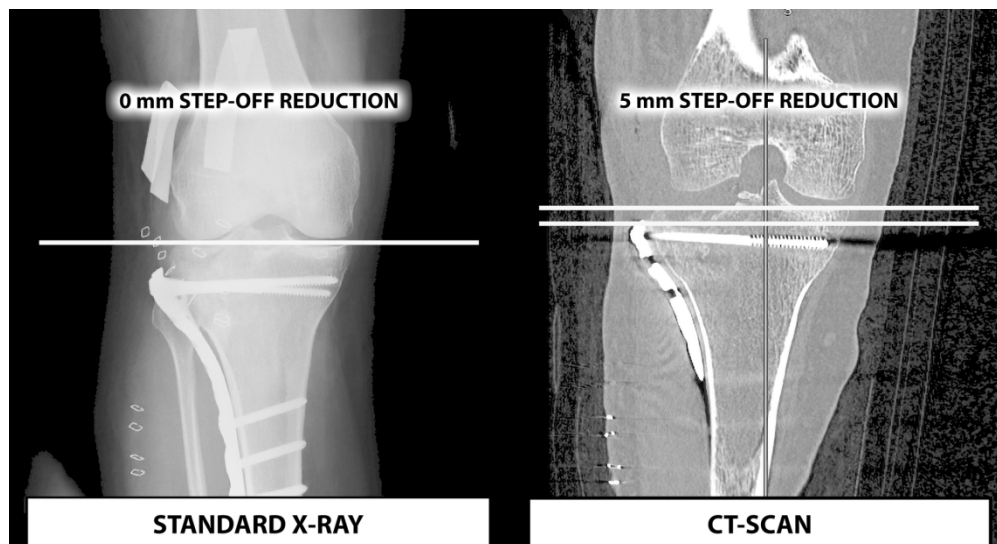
A radiological comparison between standard X-Ray and CT-scan (adapted from Haller et al., 2015)
